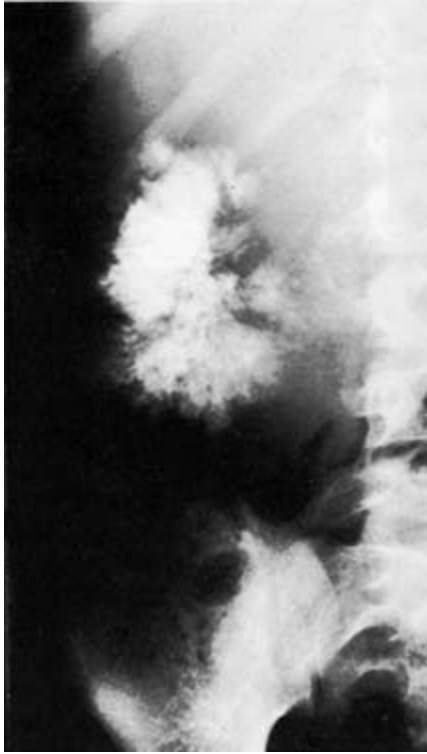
Primary liver cancer. A plain X-ray of the abdomen shows calcification (sunburst lesion).
